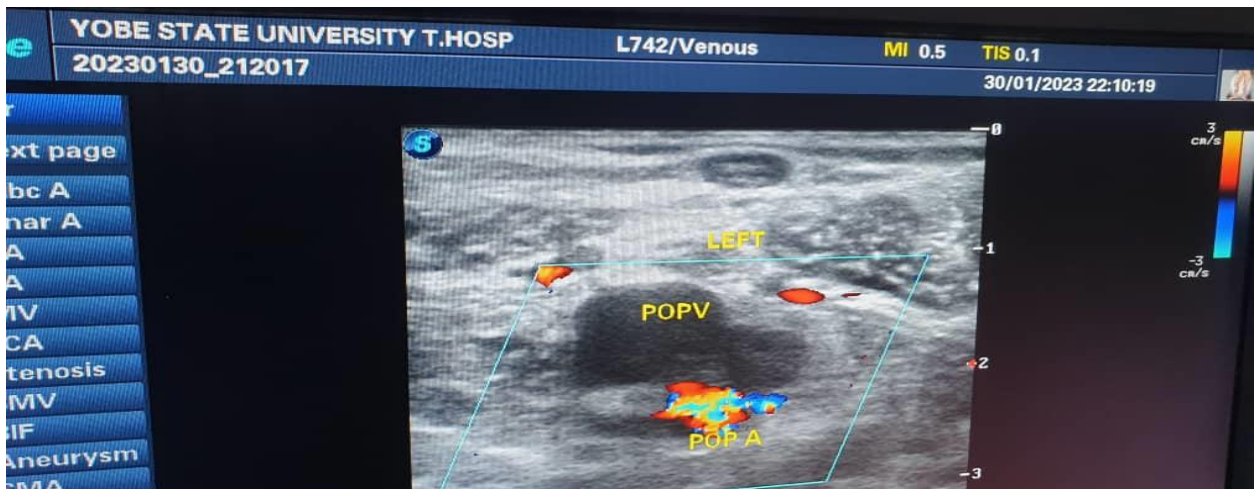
High resolution sonogram of the thigh with colour Doppler in transverse section showing filling defect in the left popliteal vein due to thrombus.
